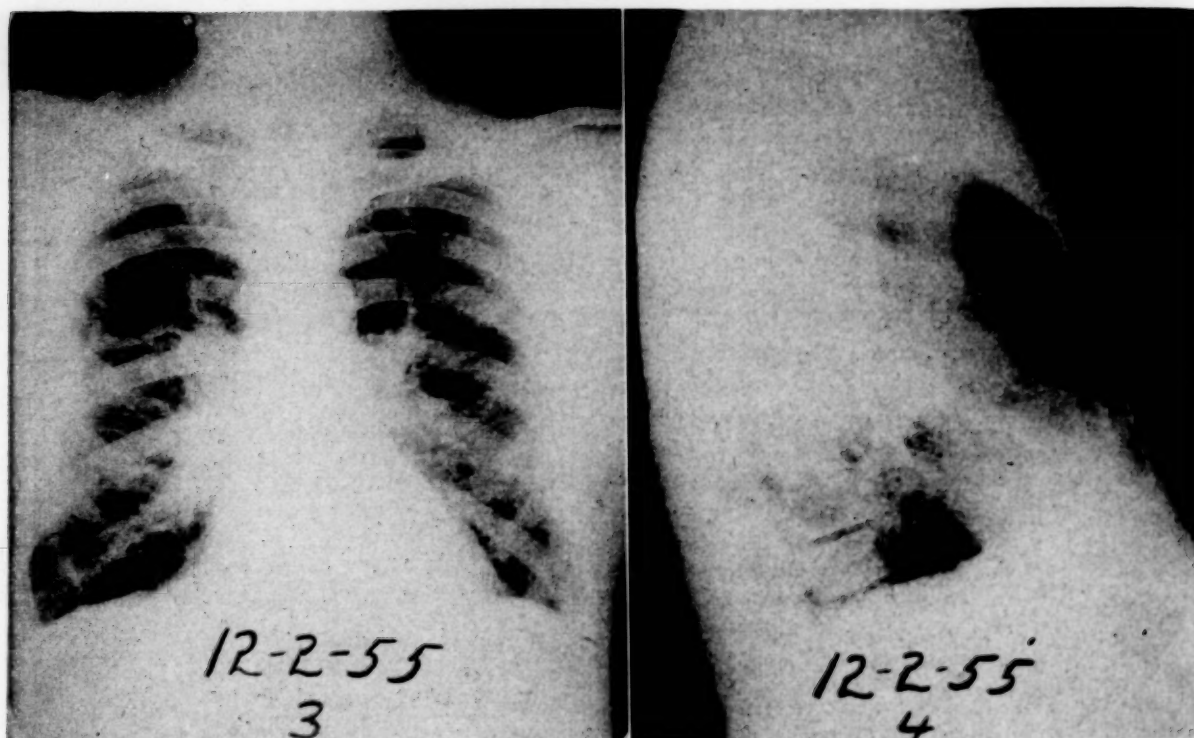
CASE VII. Postoperative roentgenograms showing re-expansion of right upper lobe and slight reduction in cardiac contour.
